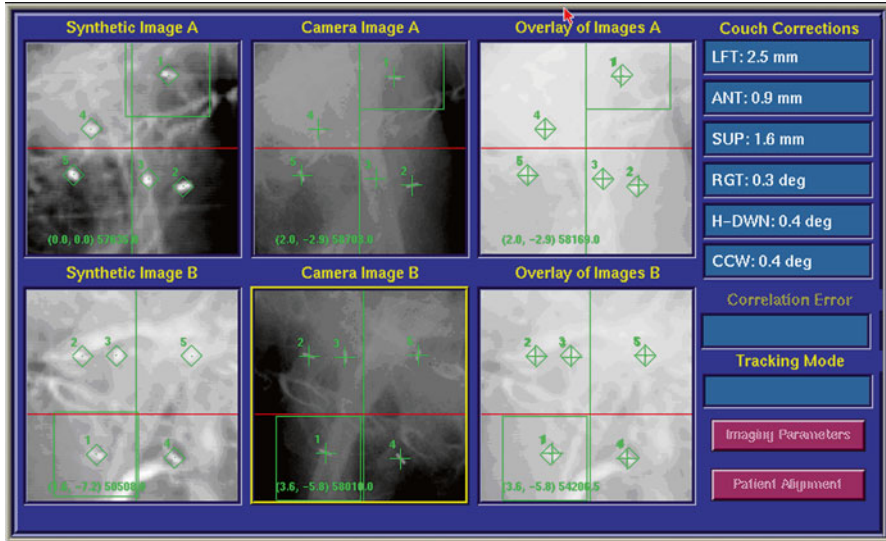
Alignment of the tumor with the use of implanted fiducial markers. A screen dump of the digital display at the CyberKnife treatment console taken before treatment in order to align the tumor. In the *first column*, the DRR is shown. In the *green cubes*, the markers on the DRRs are shown. In the *second column*, 2 orthogonal images of the patient are shown. The *green crosses* indicate the marker positions detected automatically by the tracking software. The offsets between the target centroid position in the treatment plan and that calculated from the live X-ray images are shown under the heading “Couch Corrections.” Initially this information is used to automatically adjust the couch position. Once treatment starts, the couch remains static and all tracking is performed using the robotic arm and LINAC. The *third column* shows an overlay of the DRRs and the X-ray images after the calculated offsets are applied
